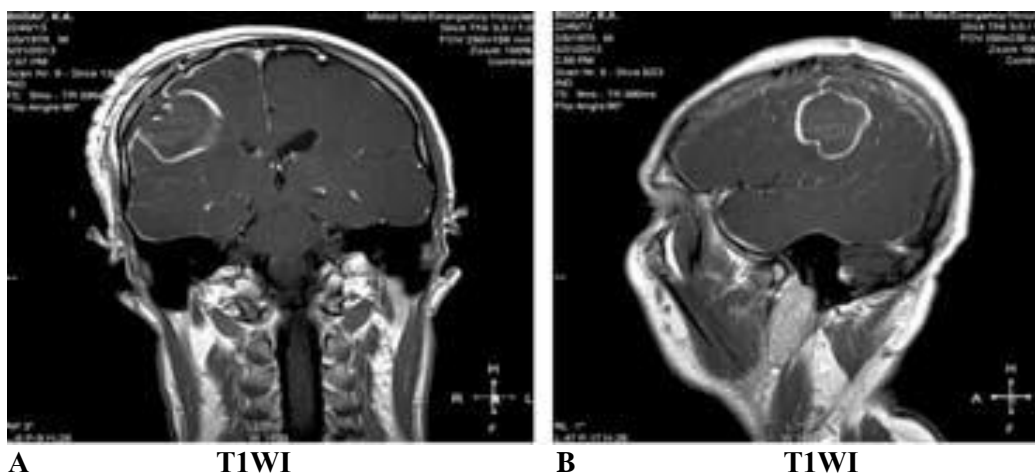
MRI of patient B., 43 years old. Diagnosis: glioblastoma of the right parietal lobe. Postoperative cyst with a fluid component. A – T1WI mode in frontal projection. B – T1WI mode in sagittal projection on the 10th day after the surgery
